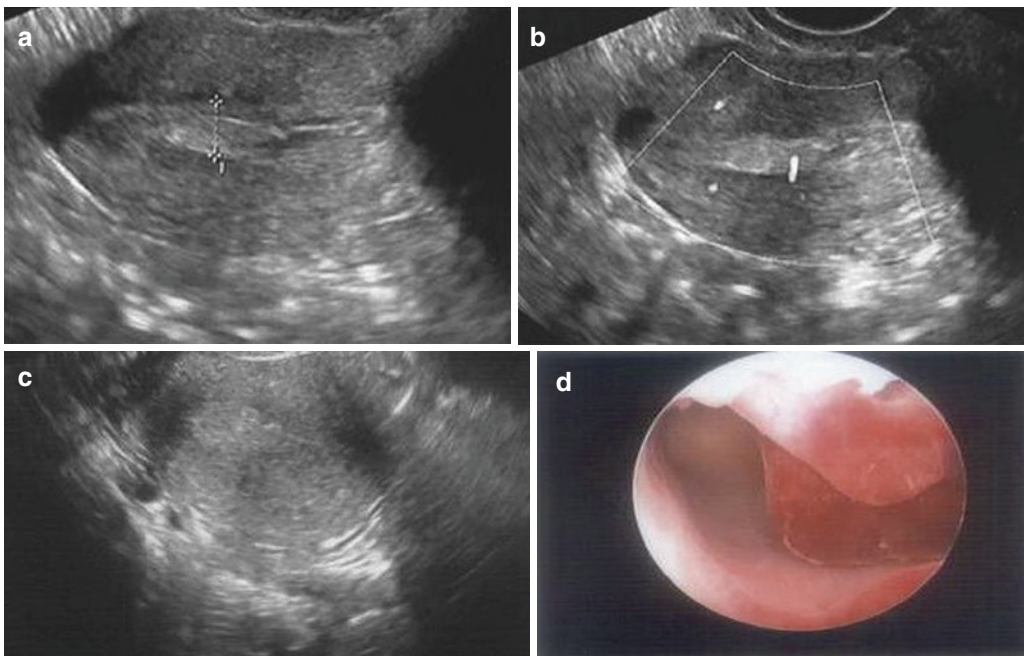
Transvaginal ultrasonographic view of an endometrial polyp (a, *cursor*) appearing as an echogenic ovoid structure containing a feeding vessel visualized by
